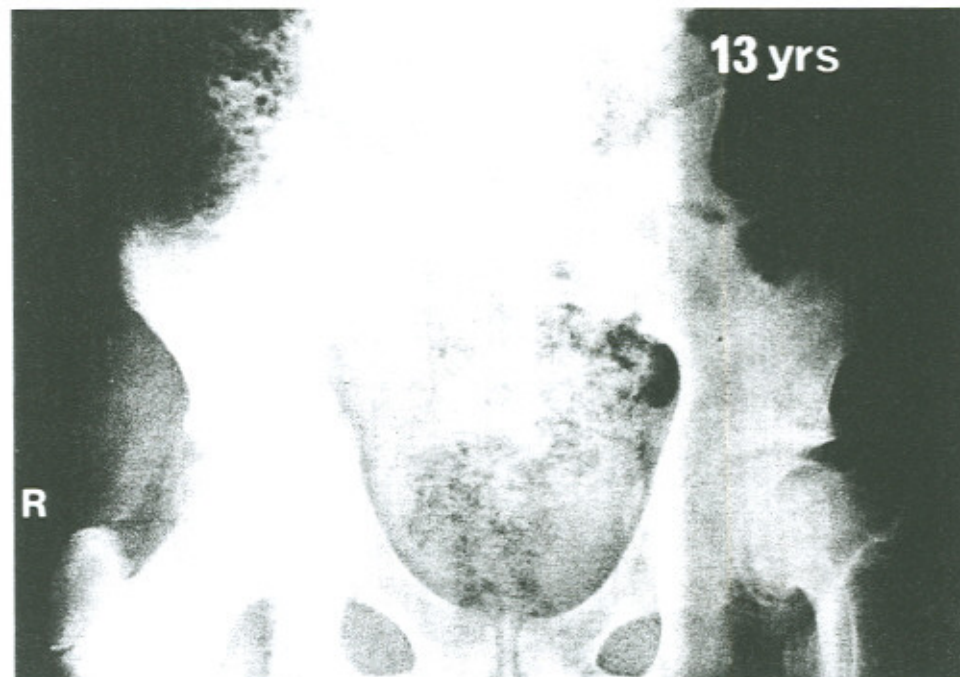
An anteroposterior pelvic radiograph of the same child in figure 3 taken one year later. There is an advanced slip of the left capital femoral epiphysis.
